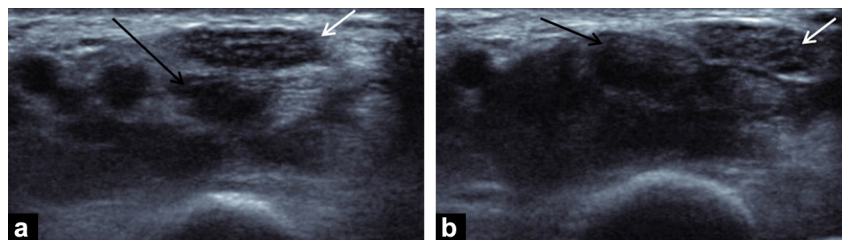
Dynamic ultrasound during flexion-extension movement of the fingers shows good mobility of the median nerve (white arrow) in the transverse plane on a background of persistent symptoms after carpal tunnel surgery. This argues, in our experience, against a nerve release failure. a: normal position of the median nerve during fingers extension; b: normal lateral translation of the median nerve above superficial flexor tendons (black arrows) during fingers flexion.
